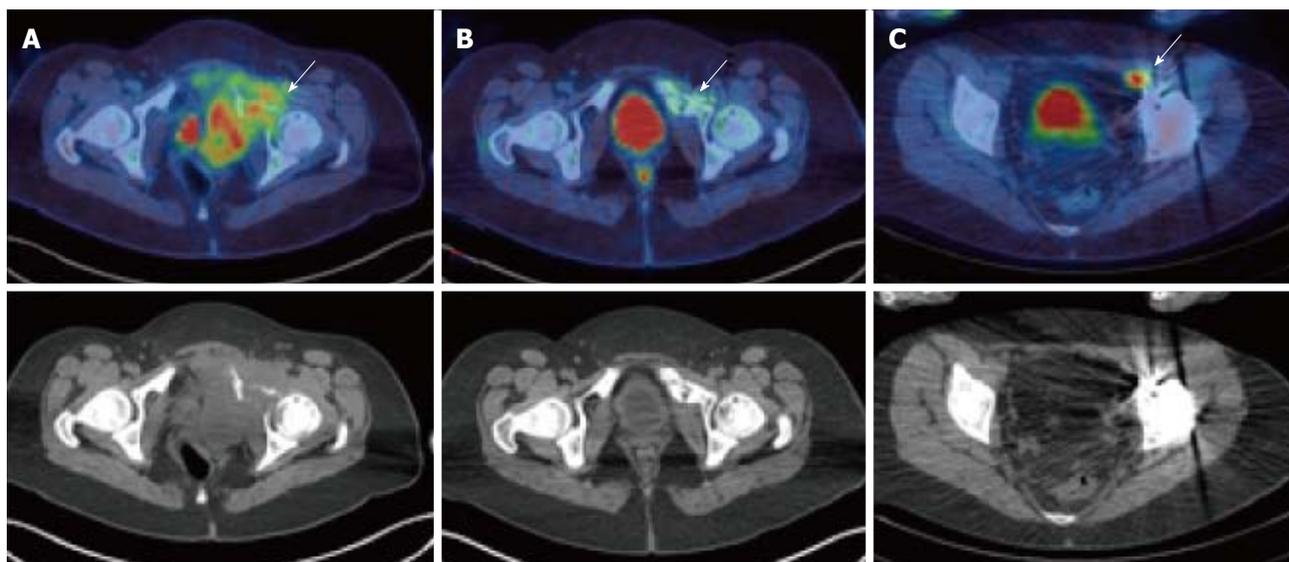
A 17-year-old female with Ewing's sarcoma involving the left superior pubic ramus. Staging PET/CT showed extensive disease (A, arrow) with bone destruction and a large FDG-avid pelvic mass. Following chemotherapy, at 5 mo after diagnosis, there was an excellent metabolic response with minimal residual FDG uptake (B, arrow). Patient underwent surgical resection and extracorporeal radiotherapy to the bone. Sixteen months after completion of treatment, surveillance PET/CT demonstrated recurrence in a left external iliac lymph node (C) which was not detectable on the CT or MRI due to marked metal artefact. PET/CT: Positron emission tomography/computed tomography; FDG: 2-deoxy-2-(^{18}F)fluoro-D-glucose; MRI: Magnetic resonance imaging.
